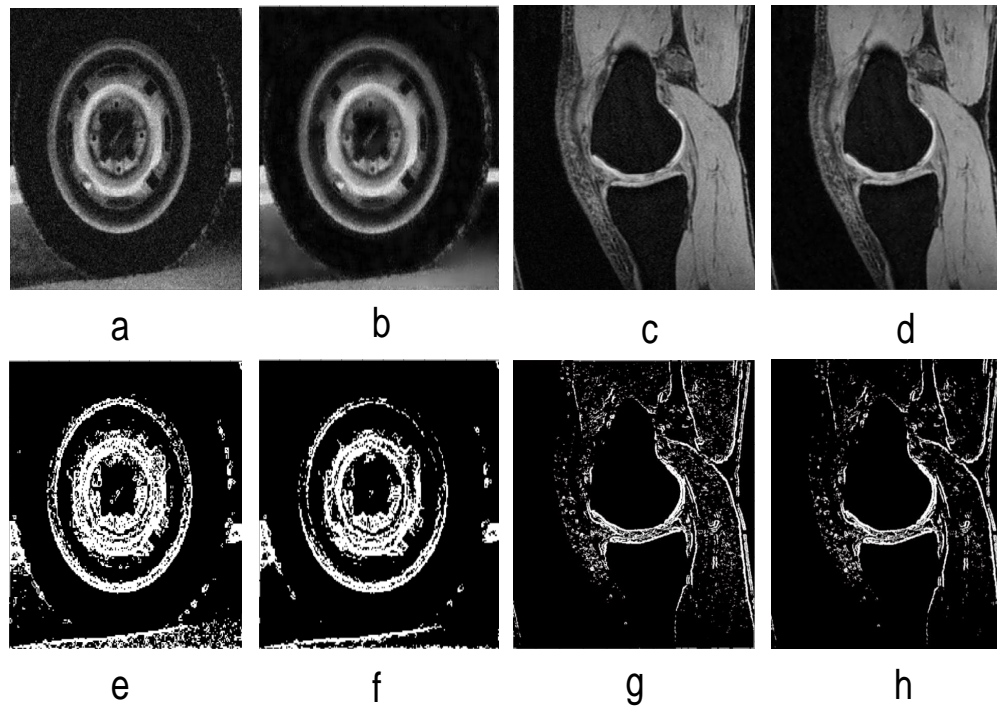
a) Tire.tiff with Rician noise of standard deviation 20, b) Denoised tire.tiff image, c) Noisy MR image d) Rician denoised MR image e) Edge output with proposed method for noisy tire image, f) Edge output with proposed method for denoised tire image, g) edge output with proposed method for noisy MR image and h) edge output with proposed method for denoised tire image
